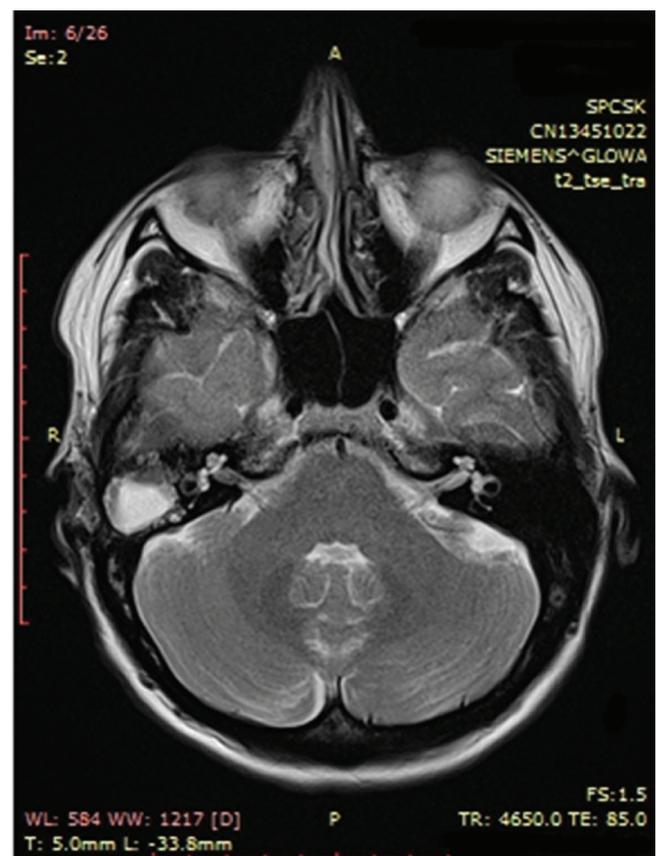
T2-weighted MRI of the head, axial view, showing a meningoencephalic herniation on the right side
